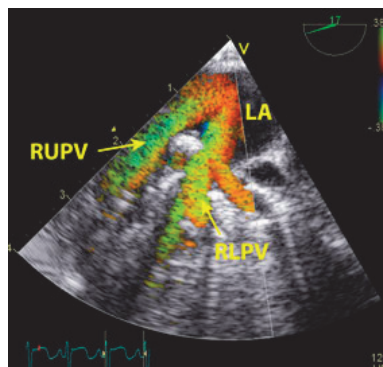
Transesophageal blood flow imaging in the visualization of the right upper (RUPV) and right lower pulmonary vein (RLPV) entering the left atrium (LA). A movie clip of this figure can be seen in the corresponding movie clip S3.
